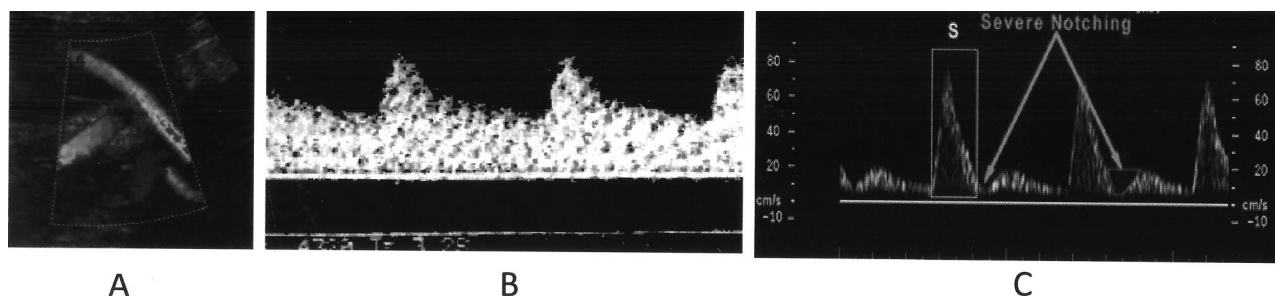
Maternal uterine artery Doppler flow studies. (A) Maternal uterine artery imaged on color flow mapping as it crosses the internal iliac vessels. (B) Normal wave form pattern at 32 weeks. Note the soft systolic peaks and high level of forward diastolic flow. This is consistent with a low resistance, high flow circuit. (C) Abnormal wave form from an opiate-dependent patient in moderate withdrawal. Note the high, sharp systolic peak early diastolic notching and low level of diastolic flow. This is consistent with a low flow, high resistance circuit.
